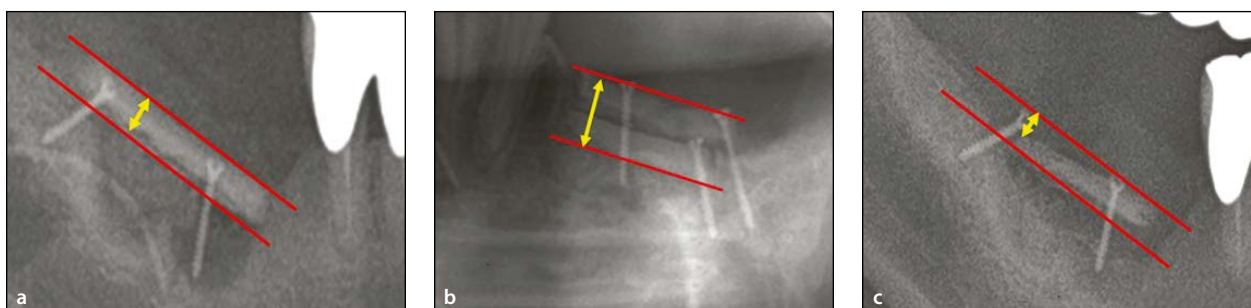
Measurement of the amount of bone gain and resorption amount. (a) Vertical alveolar bone gain was measured using immediate postoperative radiograph. Distance between the upper margin and lower margin of the onlay bone was calculated at the mesial, middle, and distal areas, and the average value was obtained. (b) Two bone blocks were augmented. (c) At 6 months after bone grafting, the distance between the top of the screw head (or implant) and the most upper level of bone-to-screw (or implant) contact was calculated in the mesial, middle, and distal areas of the grafted bone, and an average value was obtained; the average values were compared with those in postoperative radiographs.
